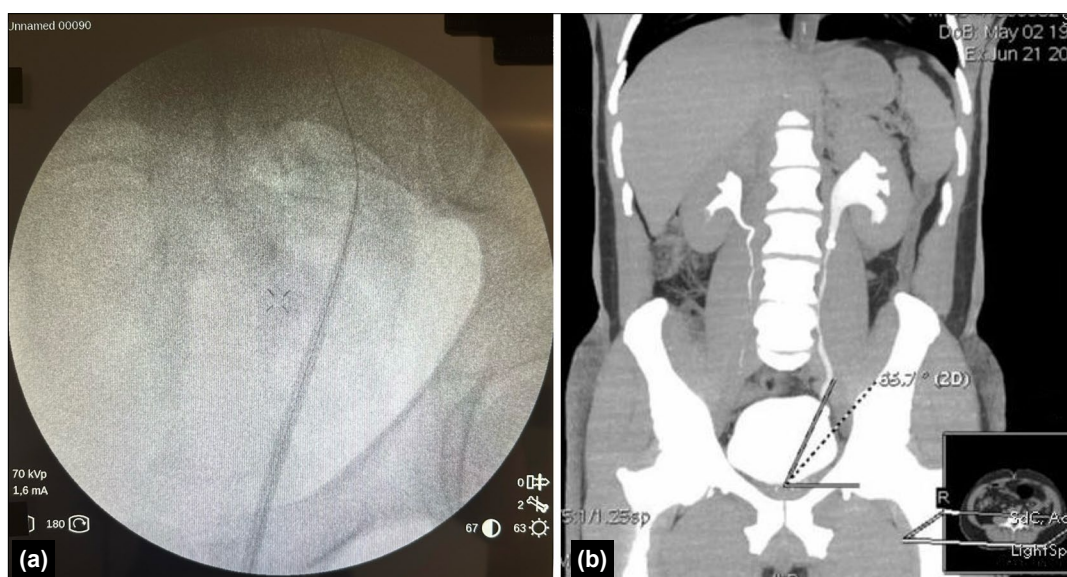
(a). Endoscopic visualization of the ureteral access sheath unable to be advanced due to the distal ureteral lateralization angle. (b) Angle measurement calculation, depicted using a computed tomography (CT) urography phase from a patient in the study to enhance the clarity of the description compared to non-contrast CT.
